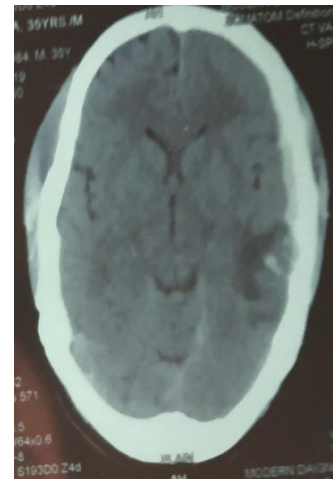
CT scan (A) shows left temporoparietal SDH; (B) shows repeat CT head reduction of left temporoparietal SDH.
